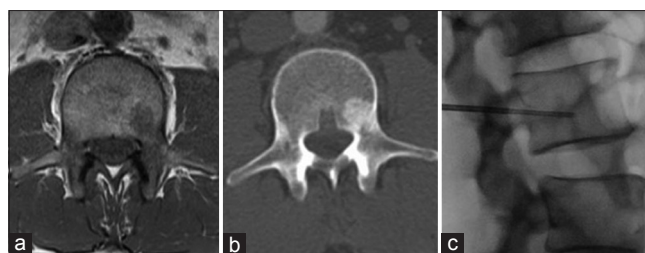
Fluoroscopy-guided vertebral biopsy in a 55-year-old male with pancreatic ductal adenocarcinoma. T1-weighted axial magnetic resonance image of a 1.8-cm hypointense mass in L3 vertebral body (a). Axial computed tomography scan of sclerotic lesion in the corresponding area of the L3 vertebral body (b). Percutaneous biopsy performed with a left transpedicular approach under fluoroscopic guidance (c)
